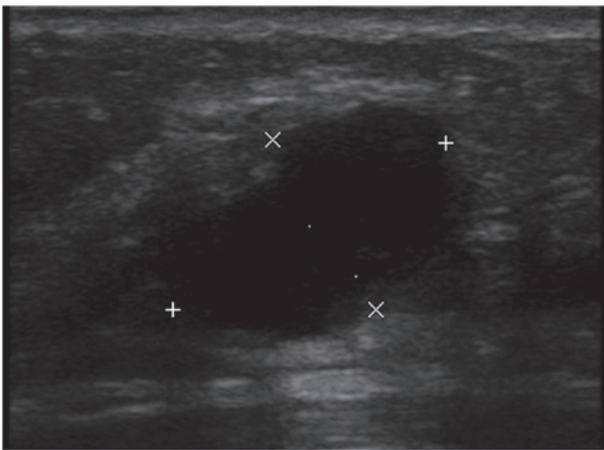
Sonographic examination revealing an irregular, partially ill-defined, hypoechoic mass with a diameter of 2.1 cm. The mass was diagnosed as grade 4B, according to the Breast Imaging Reporting and Data System classification.
